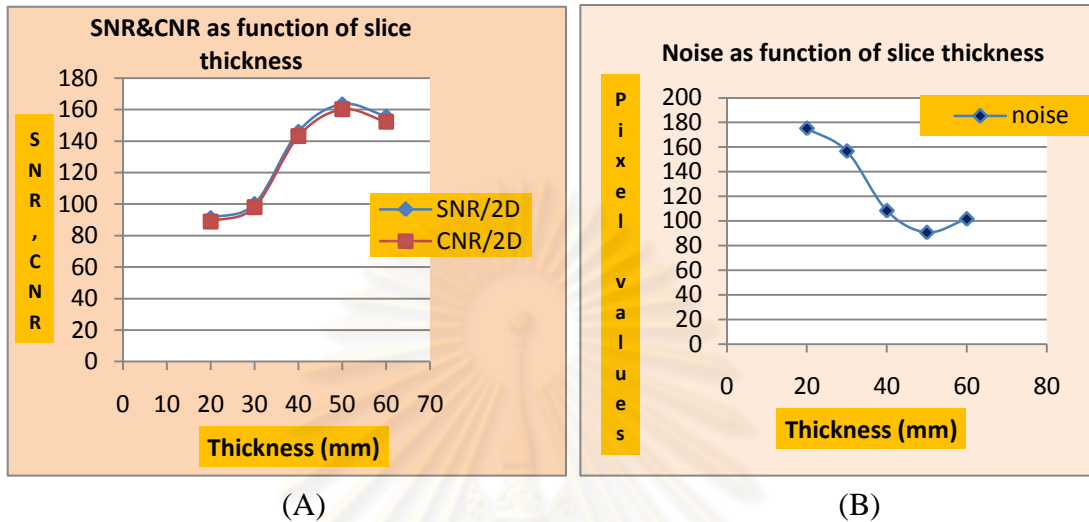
The SNR & CNR (A) and noise (B) as function of slice thickness on 2D coronal plane MRCP imaging at MRI 0.4 T
